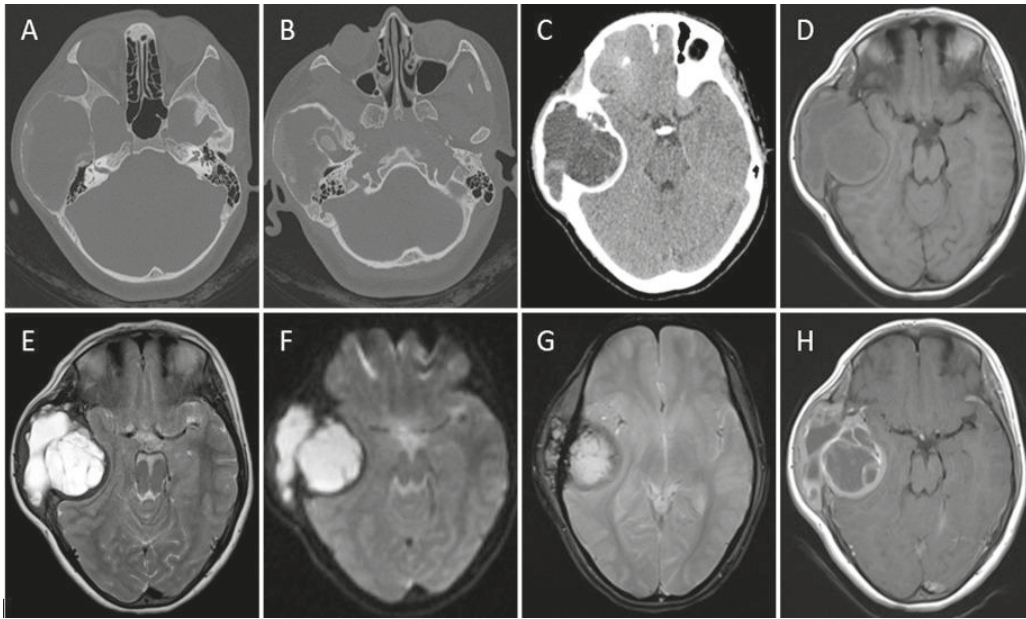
(A, B) Axial sections of HRCT of temporal bone showing a multiloculated expansile lytic lesion centered in the squamous part of right temporal bone with peripheral rim of sclerosis and thin internal septations in the absence of cortical disruption (C) NCCT axial section in soft tissue window showing hypoattenuating contents within the lesion (D) T1-weighted and (E) T2-weighted MR axial images showing the lesion following fluid signal characteristics with internal septations and no evidence of fluid-fluid levels. Note the T2-hypointense rim. (F) Trace diffusion image showing marked restriction within the lesion (the corresponding ADC map, revealing low signal, is not shown here) (G) Gradient echosequence image demonstrating few intralesional foci of blooming (H) post-Gadolinium T1-weighted axial image showing avid homogenous enhancement of the septae and wall.
